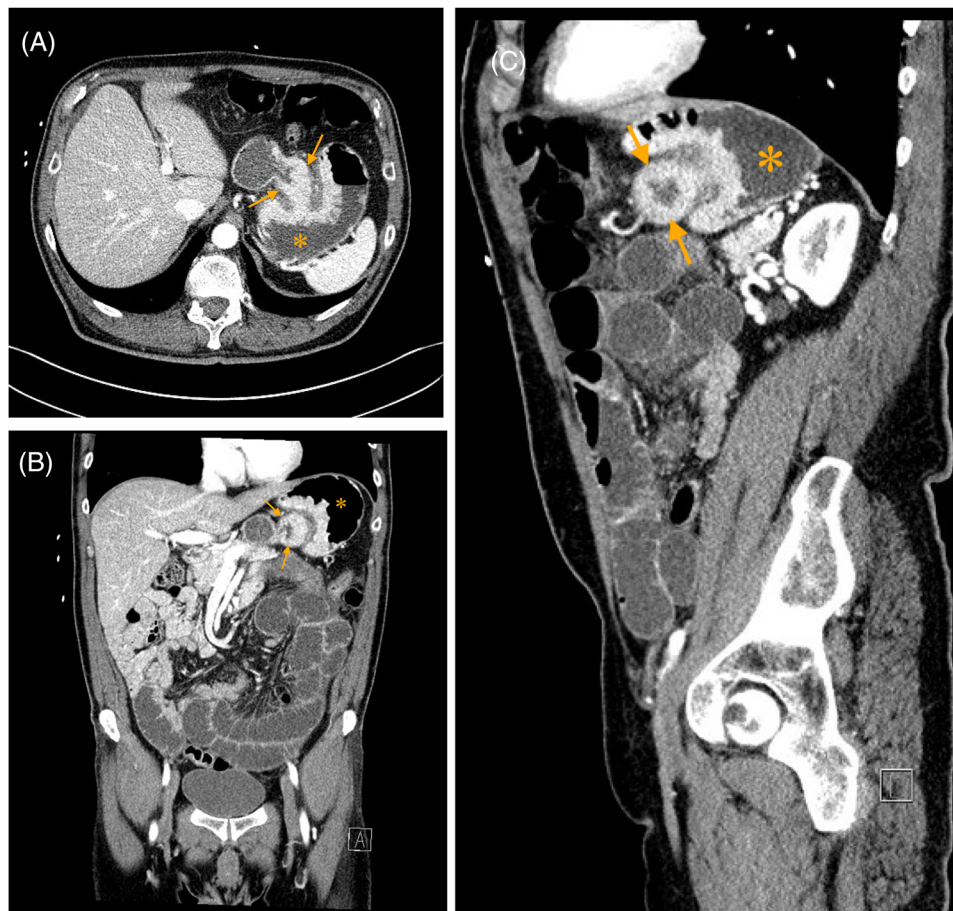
1A—Axial post-contrast computed tomography (CT) scan through upper abdomen showing gastric intussusception with distal stomach (arrows) folding antegrade into the proximal stomach (asterisk). 1B—Coronal reconstruction of post-contrast CT scan. Distal stomach (arrows) intussuscepting into proximal stomach (asterisk). 1C—Sagittal reconstruction of post-contrast CT scan. Distal stomach (arrows) intussuscepting into proximal stomach (asterisk)
